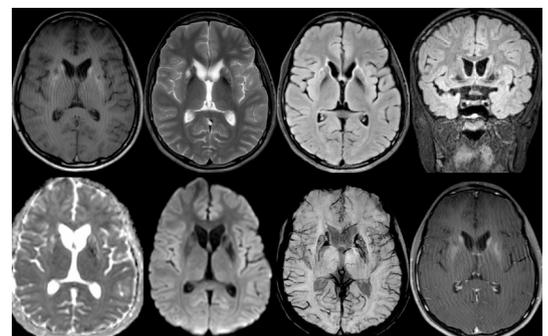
MRI brain 6 months later: bilateral striatal necrosis with resolution of T2/FLAIR hyperintensities of the above areas, bilateral striatal T1-hyperintensity without any enhancement. FLAIR, Fluid attenuation inversion recovery.
